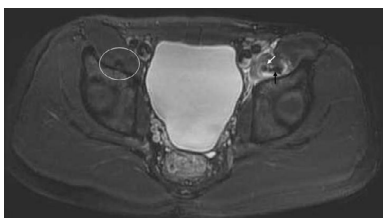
STIR axial hips MRI at level of acetabulums. As compared to the right iliopsoas tendon (white circle), the left psoas major tendon (white arrow) showed swollen and was separated from the left iliacus tendon (black arrow). High signal intensity area suggestive of hematoma is visualized mainly around the left psoas major muscle.
